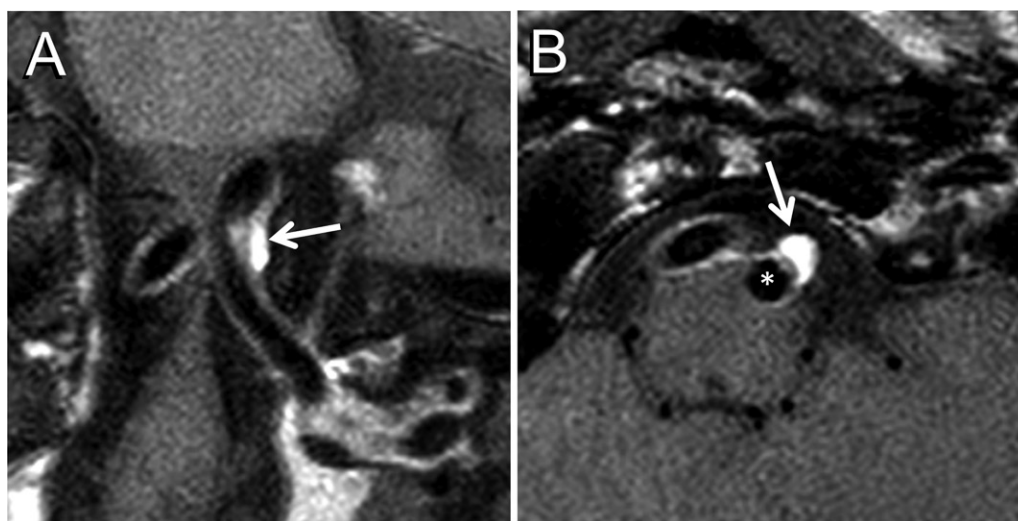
Focal benign nodular lesion at the foramen magnum mimicking atherosclerotic plaque in a 56-year-old woman with distal left internal carotid artery and middle cerebral artery stenoses. (A) Coronal postcontrast vessel wall MRI scan shows an enhancing lesion (arrow) along the lateral margin of the left vertebral artery. (B) Lesion (arrows) can be distinguished from the arterial wall on a short-axis reconstructed image.
